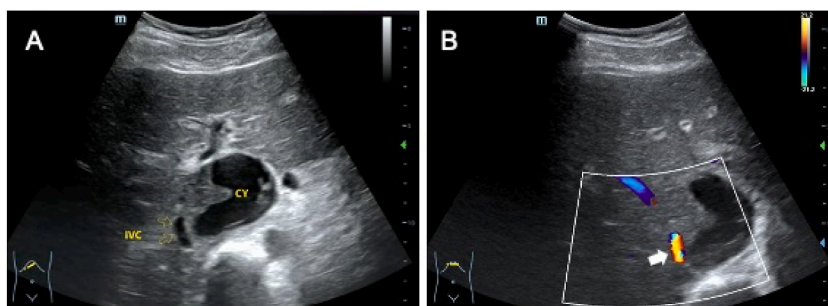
The compressed IVC due to the cystic lesion in hepatic caudate lobe. A: The compressed suprahepatic IVC on B-mode ultrasound showing the narrow lumen of the IVC; B: The compressed IVC on color Doppler ultrasound showing colorful blood flow. Yellow arrow and white arrow: the compressed IVC on B-mode ultrasound and color doppler ultrasound respectively. Abbreviation: IVC: inferior vena cava; CY: cyst.
